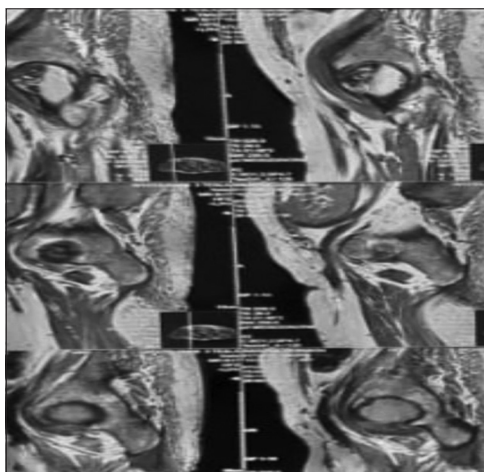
Pre-operative magnetic resonance imaging scan of right thigh and hip to depict the status of abscess and sinus
